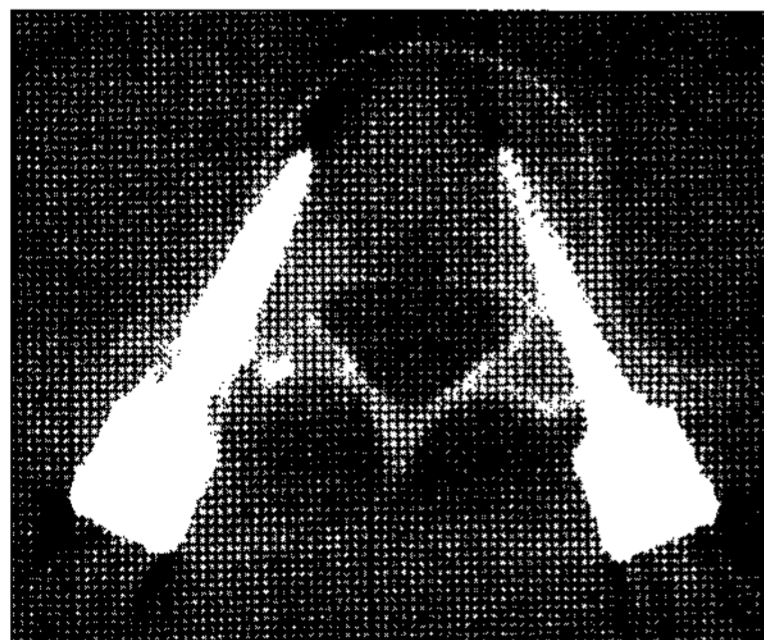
One of the example of caudal deviation to the pedicle on computed tomography scan. Right pedicle screw is detected whereas left is not definitely.
